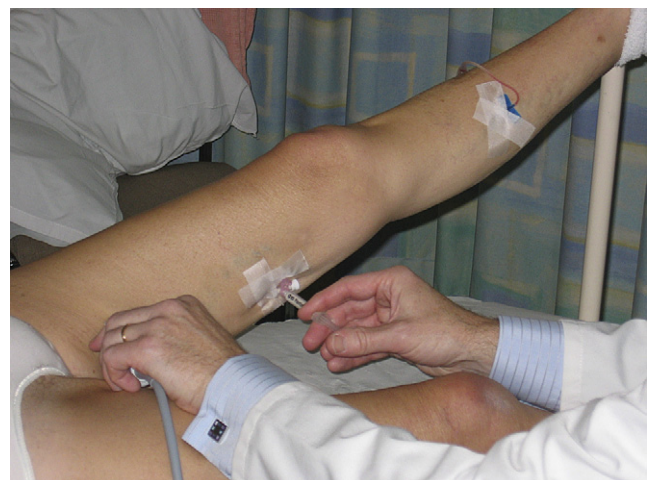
Foam sclerosant injected via Venflon into the GSV under ultrasound control.
